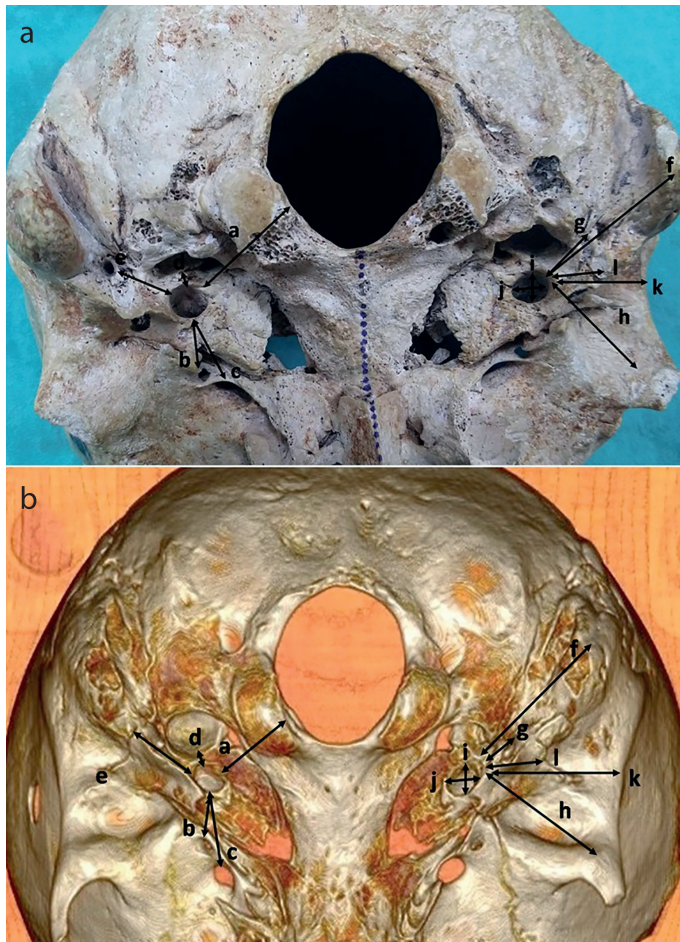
a, b. The photographs show the parameters in (a) dry skulls and (b) CT: the distance between CF and a) foramen magnum, b) foramen spinosum, c) foramen ovale, d) jugular foramen, e) stylomastoid foramen, f) the apex of the mastoid process, g) styloid process, h) zygoma root, i) CF length, j) CF width, k) supramastoid crest, and l) external acoustic porous.
